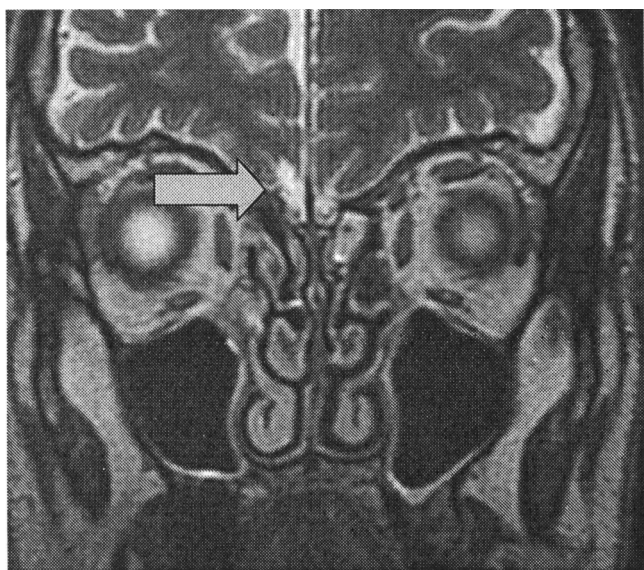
T2-weighted coronal image with decreased olfactory bulb volume and slight damage in the frontal lobe area (arrow).
